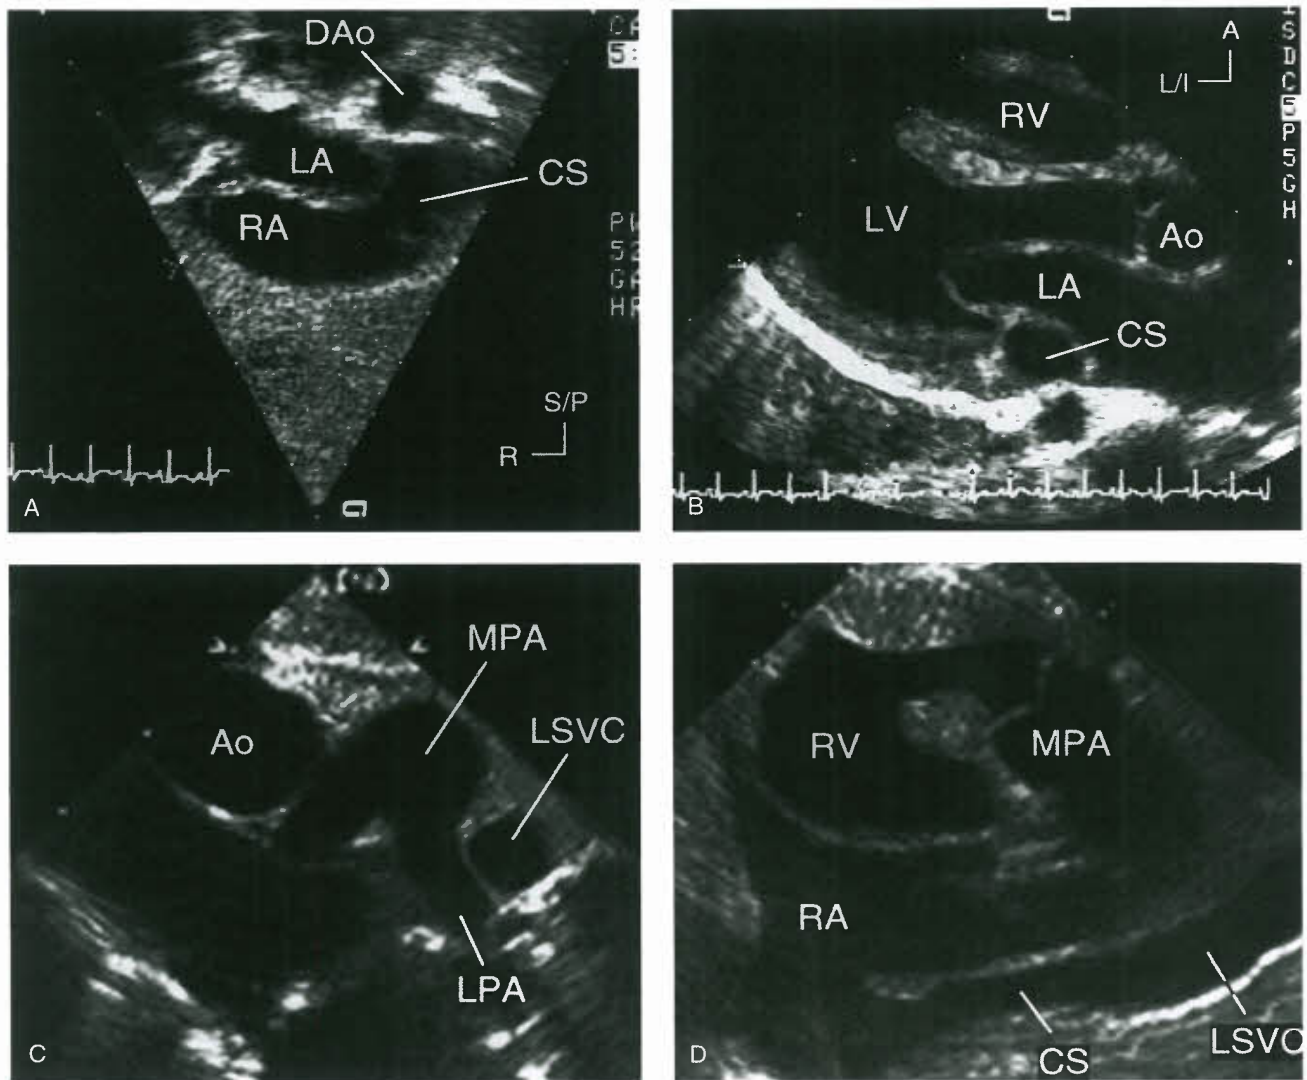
Echocardiographic features of persistent left superior vena cava (LSVC). A: Dilated coronary sinus (CS) imaged from the subcostal long-axis view. B: The dilated coronary sinus is seen in the posterior left atrio-ventricular groove from the parasternal long-axis view. C: The LSVC is seen anterior to the left pulmonary artery (LPA) in the parasternal short-axis view. D: The drainage of the LSVC to the coronary sinus (CS) and to the right atrium (RA) is seen from the high left parasternal sagittal view. A, anterior; Ao, aorta; DAo, descending aorta; LA, left atrium; L/I, left inferior; LV, left ventricle; MPA, main pulmonary artery; R, right; RV, right ventricle; S/P, superoposterior.
